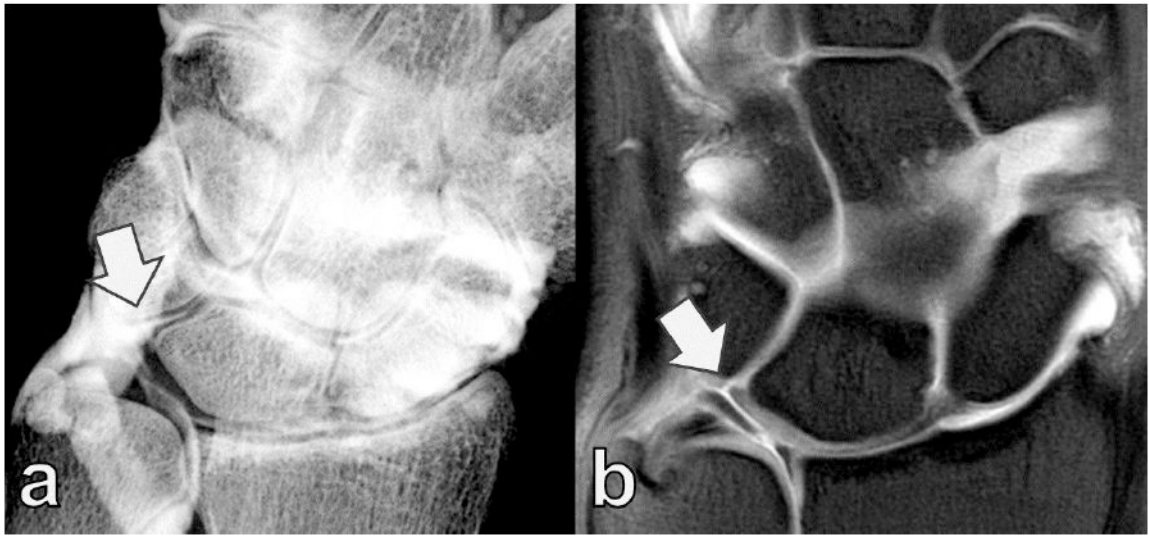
Twenty-year-old woman with full-thickness LTIL tear indicated by arrows on (a) arthrogram and (b) coronal fat-suppressed T1-weighted MR arthrogram
